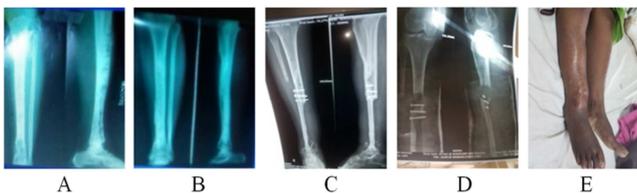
8A Pre-operative x-ray 8B post-operative at 6 yrs, complete healing of lesion & she can able to walk painlessly upto 8 yrs, 8C. After 8 yrs recurrent occur at lower part & tibialization of fibula done at that time biopsy came as admentinoma 8D & 8E. At 18 month after tibialization again recurrent occur & severe pain swelling of leg and subsequently mid thigh amputation done.
